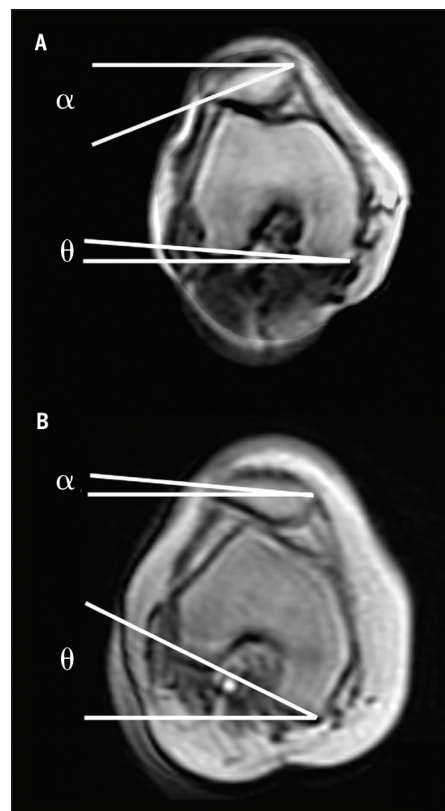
Comparison of patellofemoral joint kinematics during non-weight-bearing (A) and weight-bearing (B) conditions, as assessed using dynamic MRI. In the non-weight-bearing task (knee extension), lateral patella tilt and displacement is the result of the patella moving on a fixed femur. During the weight-bearing task (single-limb squat), lateral patella tilt and displacement is the result of the femur rotating underneath the patella. Reproduced with permission from Powers CM, et al. Patellofemoral kinematics during weight-bearing and non-weight-bearing knee extension in persons with lateral subluxation of the patella: a preliminary study. *J Orthop Sports Phys Ther.* 2003;33:677-685.
